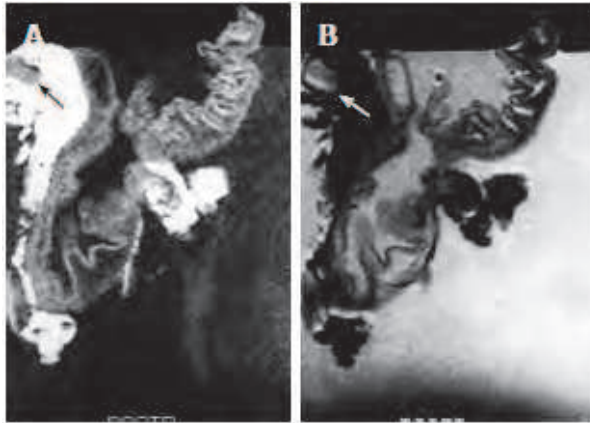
MRI of N1 Gastric Carcinoma. A: T1-weighted (500/20) MR image showed single lymph node on lesser curvature site of stomach body (Arrow); B: T2-weighted (2000/90) MRI showed intermediated signal SI of lymph node (arrow) (Kim, I., et al. 2009).
